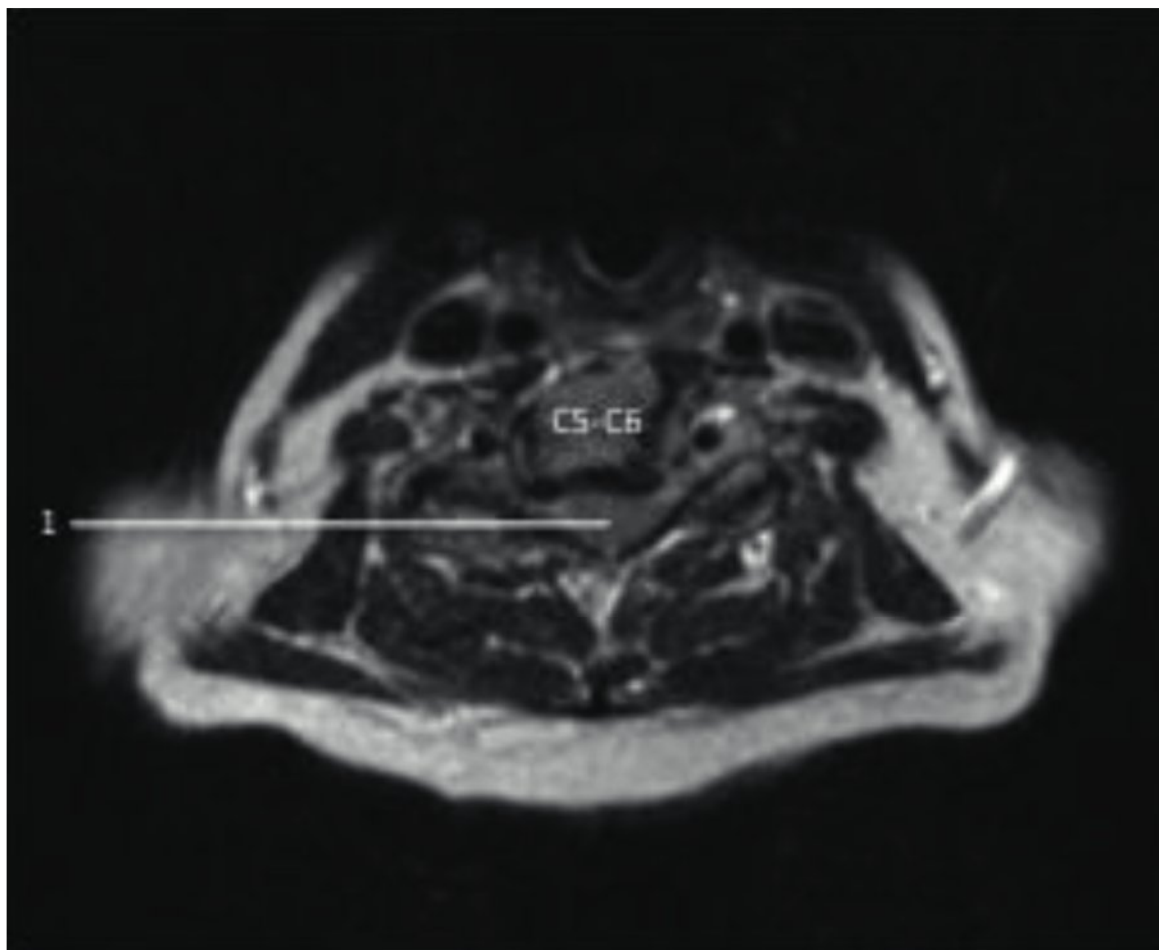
Magnetic resonance imaging axial cut at C5–C6 disk space: severe spinal stenosis. 1, central spinal stenosis (note the absence of high-signal cerebrospinal fluid surrounding the spinal cord).
